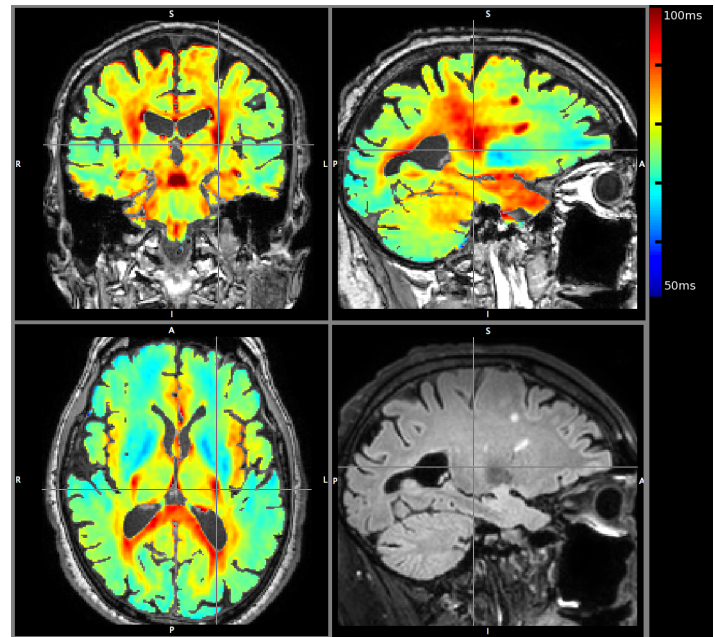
T_{1ρ} map and T2-FLAIR from a 75 year old male.
